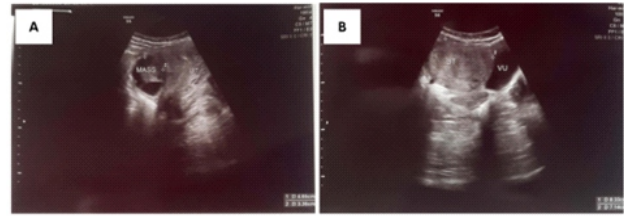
Abdominal ultrasound results
